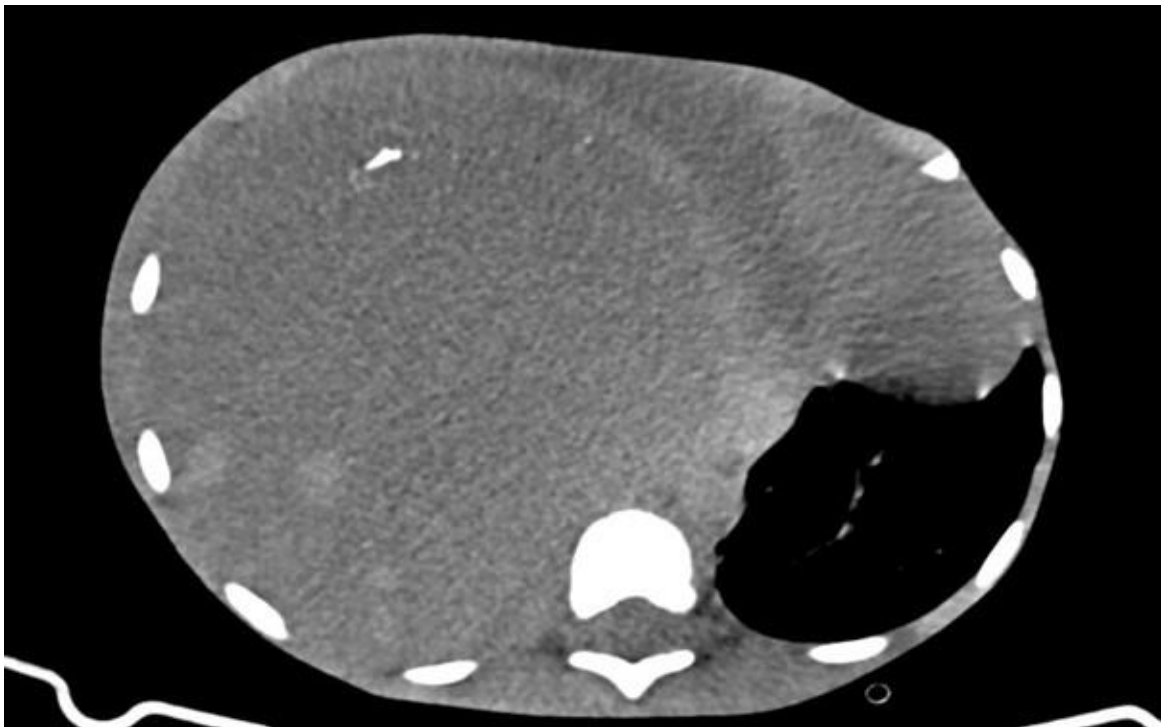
Axial section of pre-contrast CT scan of the chest on soft tissue window at the level of T6 vertebra: -there is non-visualized right lung parenchyma with right hemi-chest completely filled by large mixed cystic and solid density mass with cystic component density ranging from 13-19HU and solid component ranging 41 to 55HU. The lesion fills and replaces the right hemi-chest extending from anterior to posterior chest wall having peripheral curvilinear type of pleural based calcifications and mass effect with shifting of the mediastinum and heart to the contralateral side.
